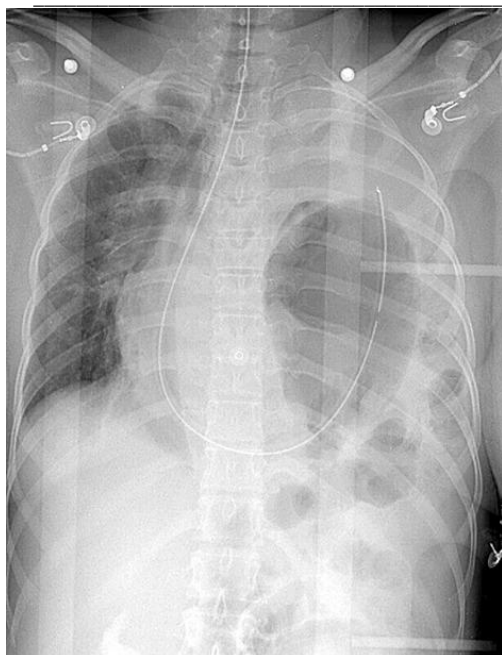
X-Ray, Blunt Chest Trauma.
